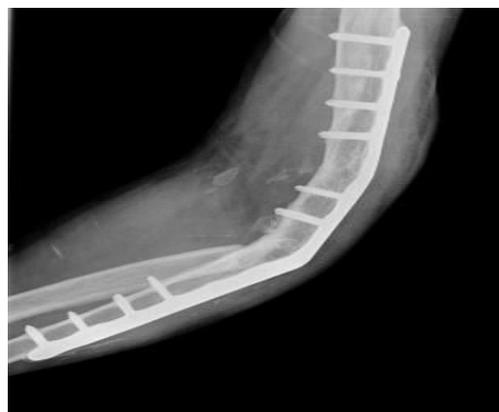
Left elbow X-ray/At 6 months post-operation
